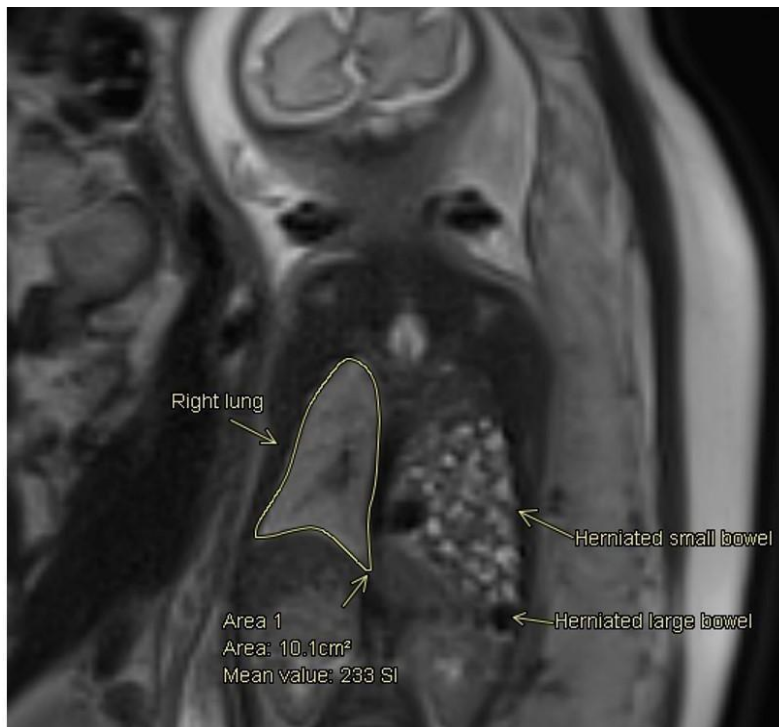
T2 Coronal MRI image of left-sided CDH with measurement of right lung volume in 32 week fetus
